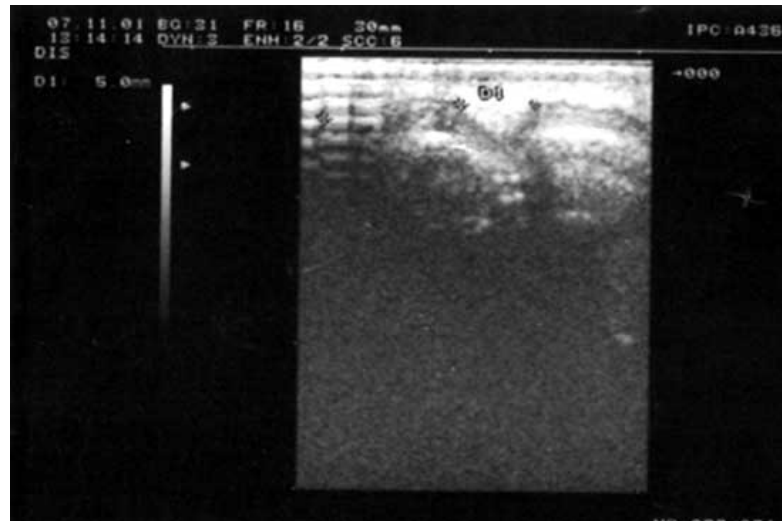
Pre-operative ultrasonogram of the patient
